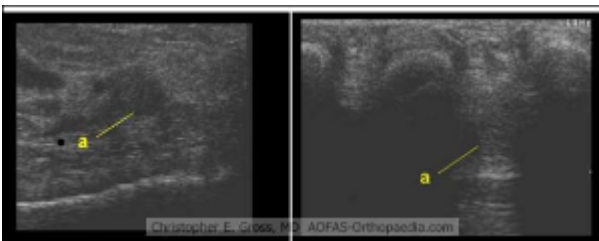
Longitudinal and transverse ultrasound views of Morton's neuroma
